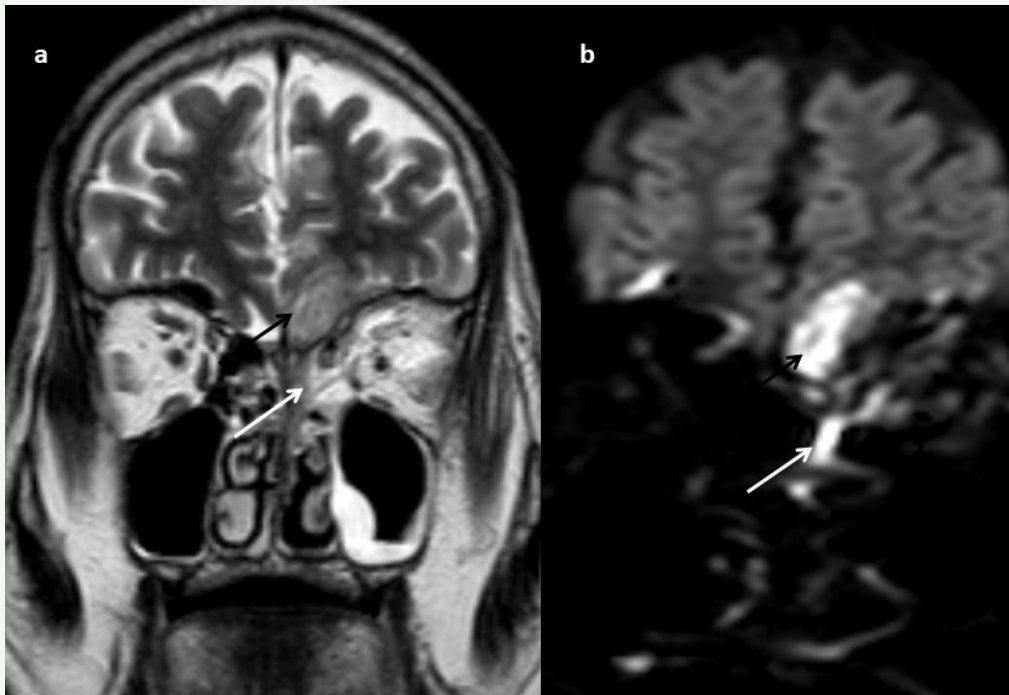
(a) Coronal T2 weighted MRI and (b) Coronal DWI show extension of infection from ethmoid air cells (white arrows) to the gyrus rectus of the frontal lobe (black arrows), across the cribriform plate. The frontal lobe lesion and the ethmoid contents show intermediate signal intensity on T2-weighted image and restriction on DWI.
